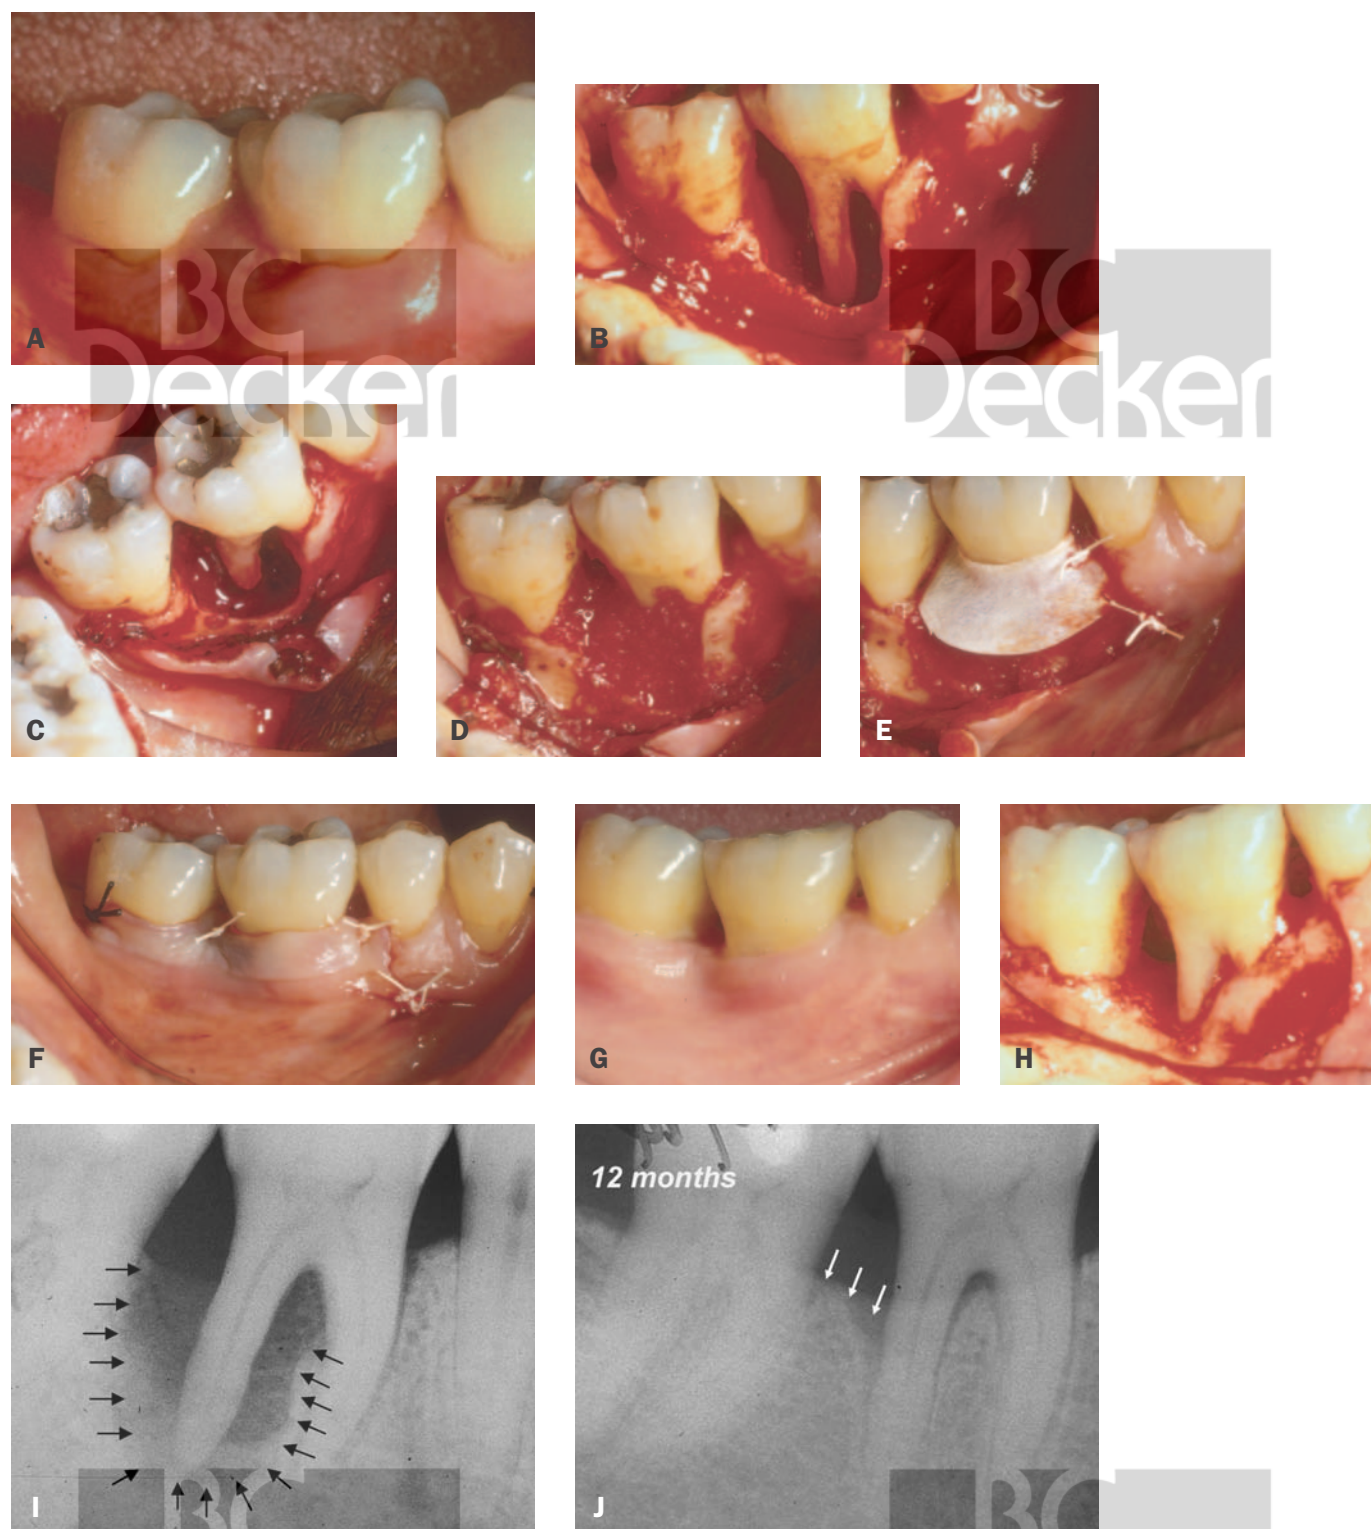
Guided tissue regeneration (grade III furcation). *A*, Before treatment. *B*, Grade III furcation and distal defect exposed. *C*, Occlusal view of a circumferential defect about the distal root. *D*, Demineralized freeze-dried bone allograft placed. *E*, U-shaped expanded polytetrafluoroethylene membrane placed. *F*, Flap repositioned with Gore-Tex sutures. *G*, One year later. *H*, Reentry after 1 year. Note complete fill of the furcation and significant coverage of the distal root with bone. *I*, Before treatment radiograph study. *J*, Radiograph study showing bone regeneration of furcation. A small residual distal defect remains.
